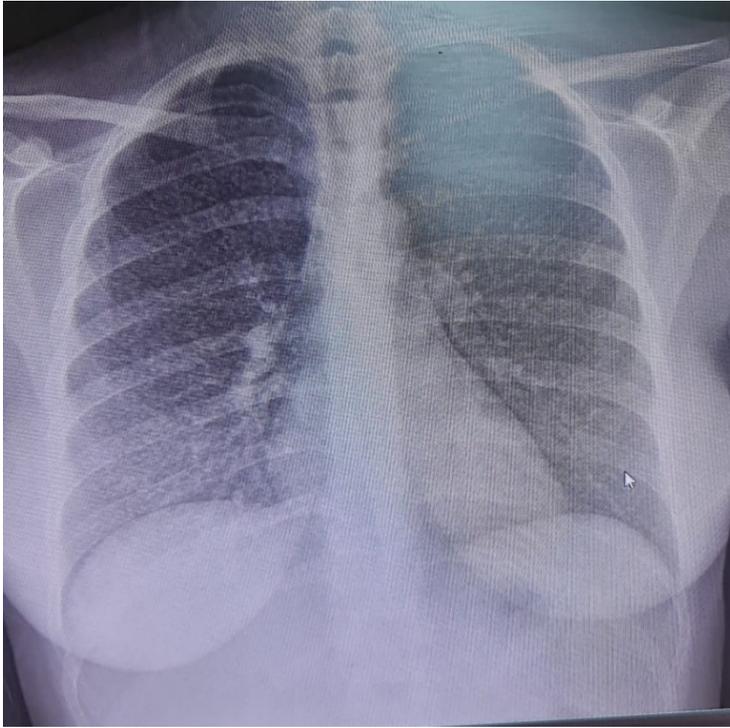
Chest X-ray image
